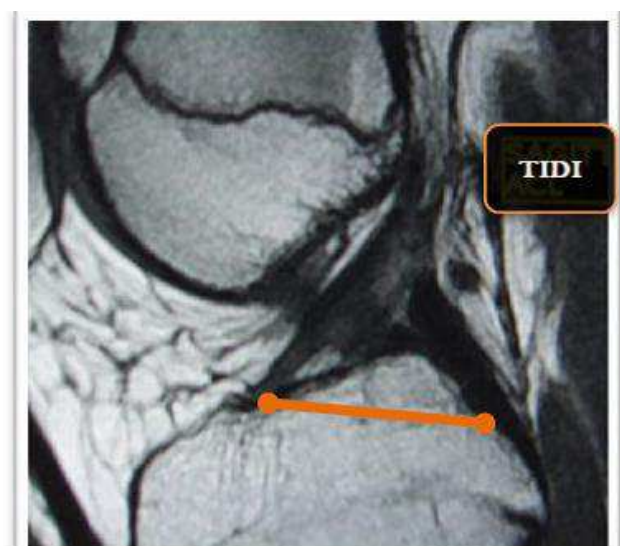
TIDI vector in sagittal MRI view.
